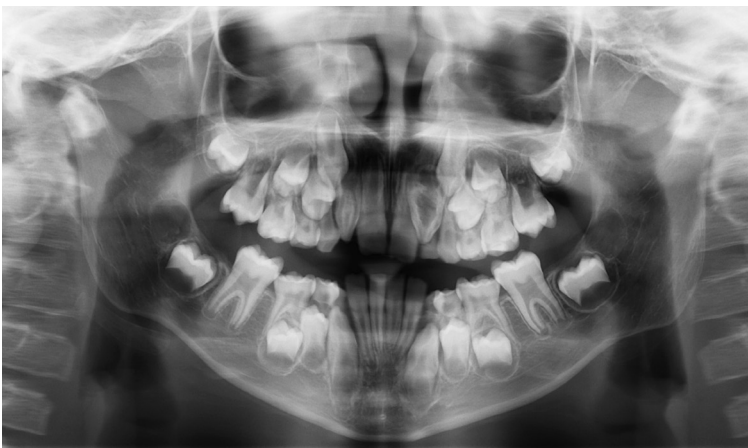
First level X-ray
